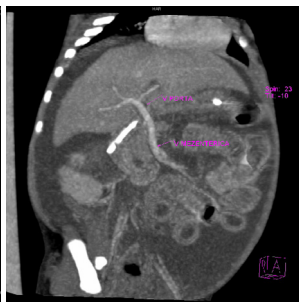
CT angiography, portal phase: absence of the splenic vein, ascites, hepatomegaly.
